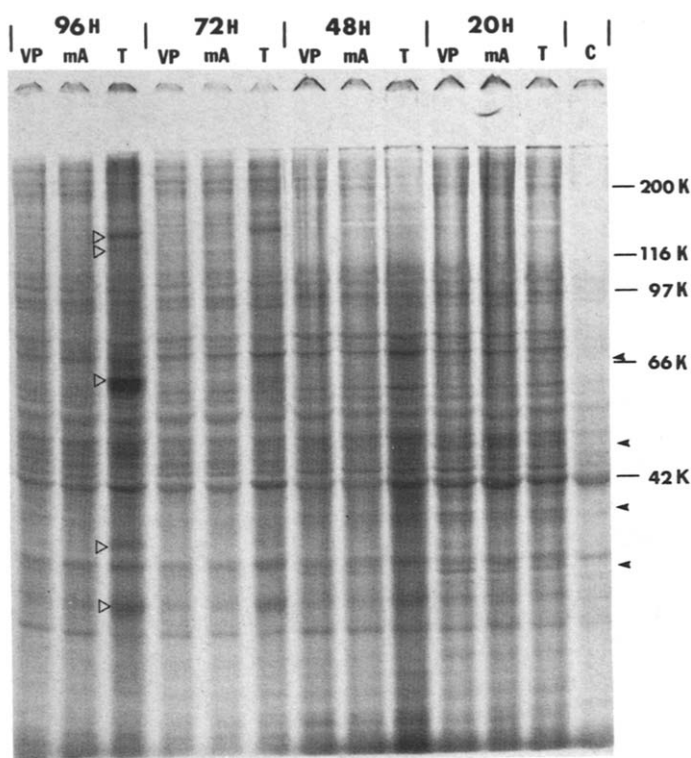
Comparison of the effect of topoisomerase II poisons on polypeptides synthesis in CMV-infected HEL cells by SDS-PAGE. Polypeptide synthesis was investigated by the incorporation of ^{35}S methionine. Infected cells were pulse-labeled with $50 \mu\text{Ci/ml}$ of ^{35}S methionine for 4 h at indicated times after infection. The polyacrylamide gel was subjected to autoradiography for 3 days with Kodak X-ray film. Molecular weight markers are indicated on the right. (C) indicates the HEL cells control; (T) Towne strain CMV infected cells without inhibitor; (mA) CMV-infected HEL cells with m-AMSA at $2 \mu\text{M}$; and (VP) CMV-infected HEL cells with etoposide at $5 \mu\text{g/ml}$ ($8.25 \mu\text{M}$). Arrow-heads indicate the peptides which had appeared at earlier stage of infection. Open-triangles show the peptides which appeared after viral DNA replication.
